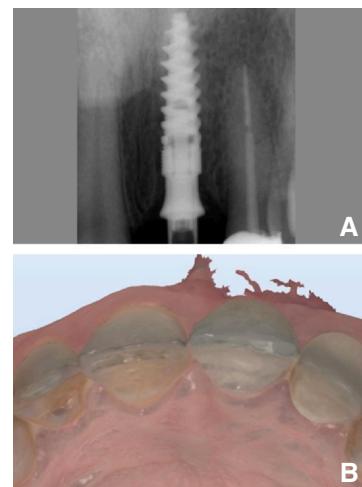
Postoperative assessment. A, Periapical radiograph confirming implant position and prosthesis fit. B, Postoperative intraoral scan of interim screw-retained crown.
